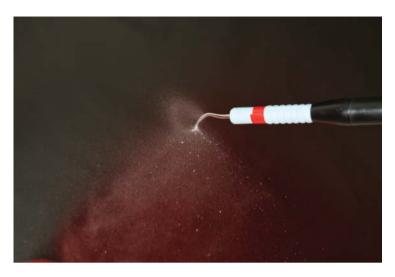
Ultrasonic scaler showing water spray effect
